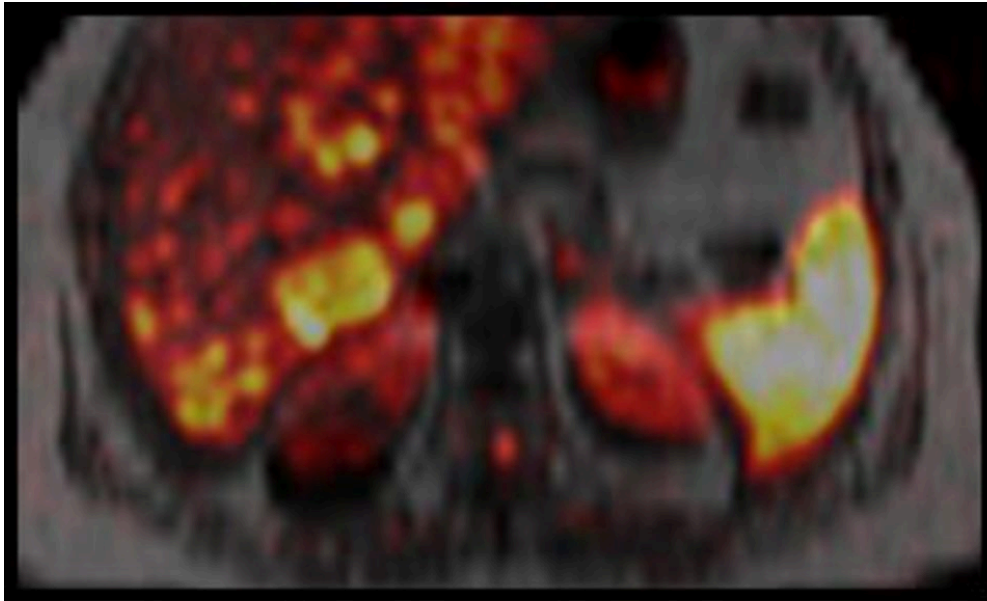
T1/DWIBS fused images show multiple metastatic lesions with restricted DWI signals
